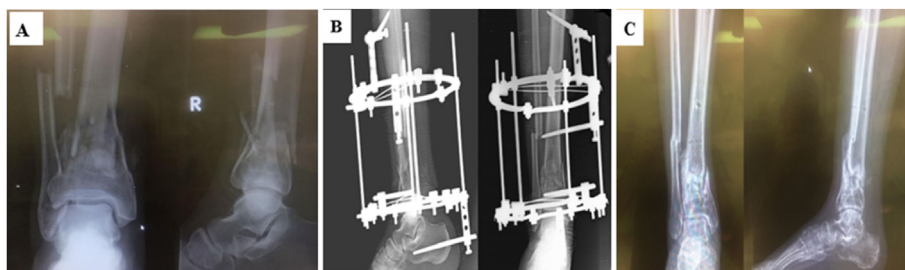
60 years old female patient presented with A3 extra-articular fracture of the right tibia and fibula treated with IE. A) AP & lateral radiographs of post traumatic fractures of lower leg bones. B) AP, and lateral radiograph of fracture fixation by ilizarov postoperatively. C) AP, lateral radiograph at last follow-up following 20 weeks and outcome was fair for subjective and objective Ovadia and Beals scoring system.
